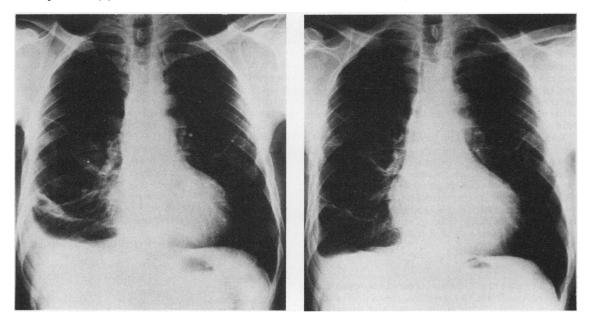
(a) Chest radiograph on admission showing bilateral pleural thickening with right-sided pleural effusion. (b) Chest radiograph two years later showing mild fibrosis on the right side.
